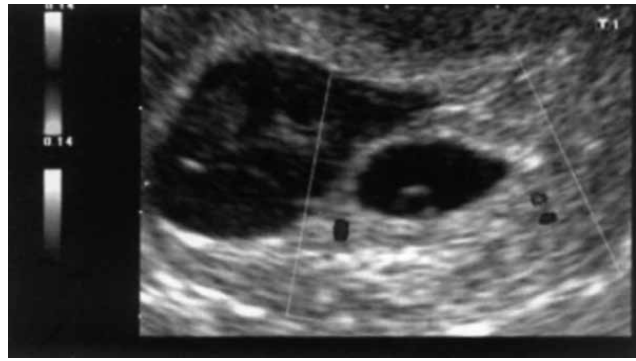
Color Doppler revealed no vascularity in the hypoechoic mass and very poor vascularity of gestational sac.
